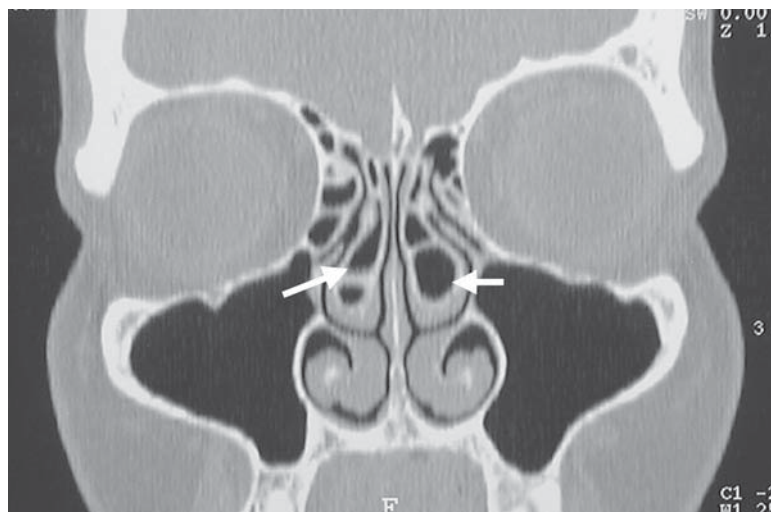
Concha bullosa: coronal computed tomography scan image of the paranasal sinuses. The arrows point to the concha bullosa in each middle turbinate. In this case, septae divide the concha bullosa into more than one air space. The usual result of the concha bullosa is enlargement of the turbinate, usually resulting in chronic nasal congestion. Infection may occur in the concha bullosa. Frequently the septum is deviated away from a unilateral concha bullosa. Therefore, this entity should be considered in a patient complaining of chronic congestion.
